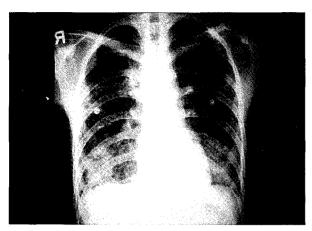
Chest radiograph demonstrates profuse ill-defined nodules and patch opacities, as well as a reticulonodular appearance predominant in the lower lung zones.
